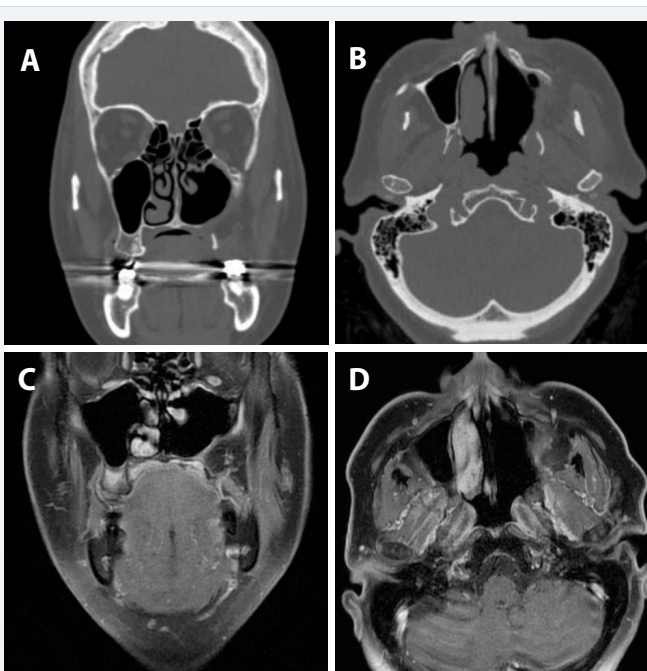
Case 2 (A) Coronal view, (B) Axial view; Post-operative CT scan of left maxillary sinus at 3 months with no tumor recurrence. (C) Coronal view, (D) Axial view; T1, Gadolinium-enhanced post-operative MRI left maxillary sinus at 12 months with no tumor recurrence, fat pad remains in place in axial view.
